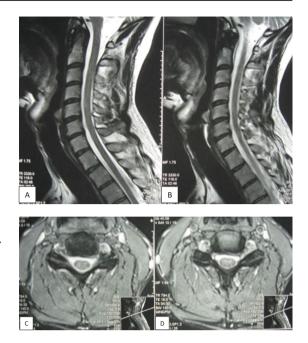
A-B)* Sagittal MRI after ozone therapy (10/09/2016) - The MRI investigation documents the complete disappearance of the herniated disc. *C-D)* Axial MRI after treatment with oxygen-ozone therapy (10.09.2016) – Complete The disappearance of the hernia.
